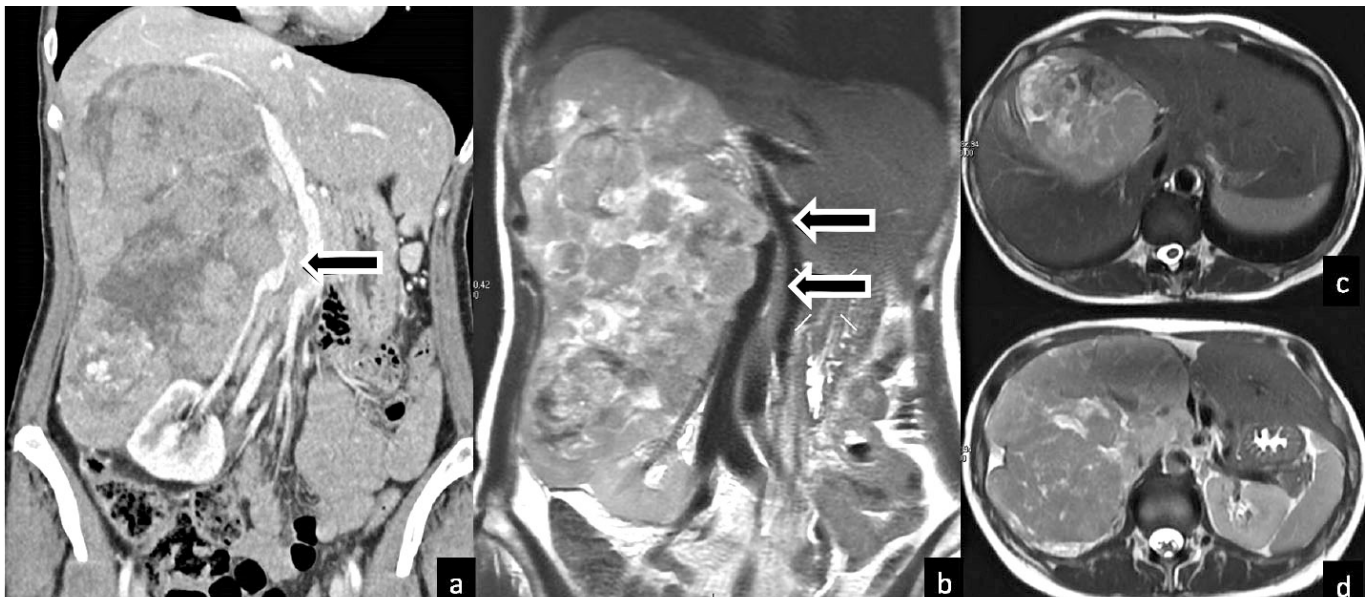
Contrast-enhanced coronal CT image (a), and coronal (b) and axial (c and d) T2-weighted MRI images show a large well defined soft-tissue retroperitoneal mass on the right extending from immediately below the diaphragm to the level of the iliac crest, and infiltrating the IVC (arrows in a and b). The mass is composed of hemorrhagic, necrotic, and calcific areas without macroscopic adipose tissue. It appears to be adherent to the right diaphragmatic crus, the right renal vein, and the right main branch of the portal vein, which is markedly thinned. The mass is indissociable from the hepatic parenchyma at the right lobe of the liver and engulfs the right adrenal gland. It displaces medially the stomach, the duodenum, and the head of the pancreas. The right kidney is displaced posteriorly and inferiorly.
